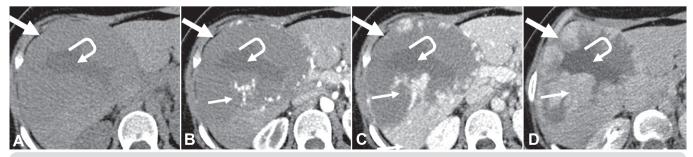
Type III hemangioma on pre-contrast (A), arterial (B), portal-venous (C), and delayed (D) phases of dynamic CT. A large liver lesion (thick arrow) with similar enhancement pattern of type II hemangioma (Centripetal discontinuous nodular enhancement – thin arrows). However, there is a "central scar", which is more hypodense than the lesion itself and do not enhance, even on delayed images. In MRI that "central scar" would be brighter than the lesion on T2-weighted images.
